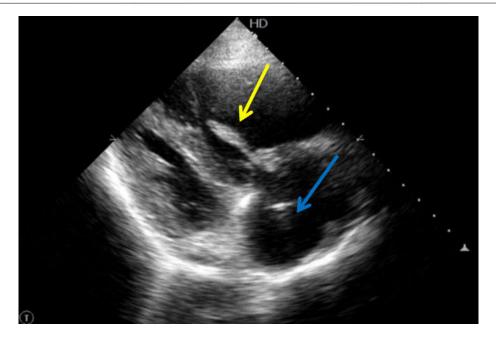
Transthoracic echocardiography showing serpentine thrombus in right ventricle
